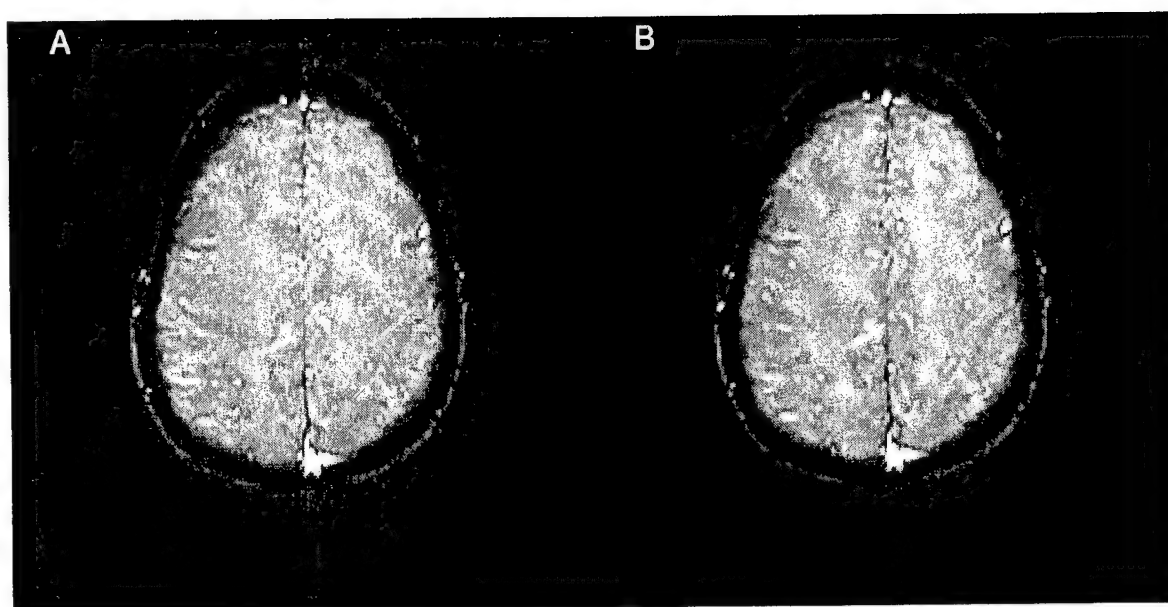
Figure A shows the original axial MR image and Figure B shows the results of forced monotonic noise suppression. The parameters were set to produce uniform areas that could be useful in segmentation. The SNR is improved significantly by forced monotonic noise suppression.
